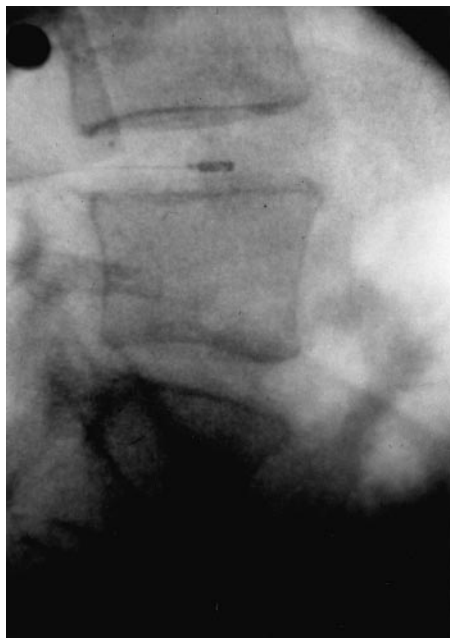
Radiograph with implanted pressure transducer approximately in the center of the L4–L5 nucleus pulposus.
